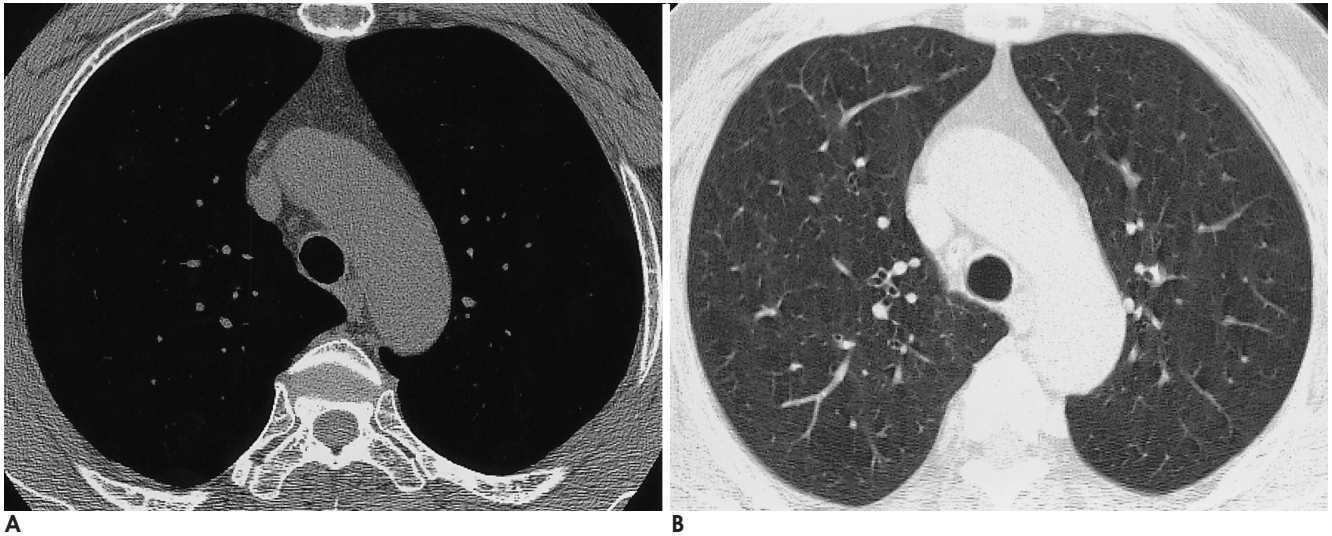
The CT section of aortic arch in a normal 63-year-old male.
